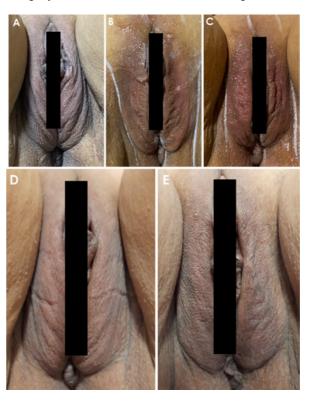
Association of Microfocused Ultrasound with collagen biostimulator: (A) Before treatment; (B) Immediate effect of HIFU (Ultraformer III® manufactured by CLASSYS INC., Seoul Korea.); (C) Right after the injection of Sculpt Derm Collagen Booster® (Cosmobeauty Ind Com Cosmetics, Brazil.); (D) 45 days after the 1st treatment session; (E) 90 days after treatment
